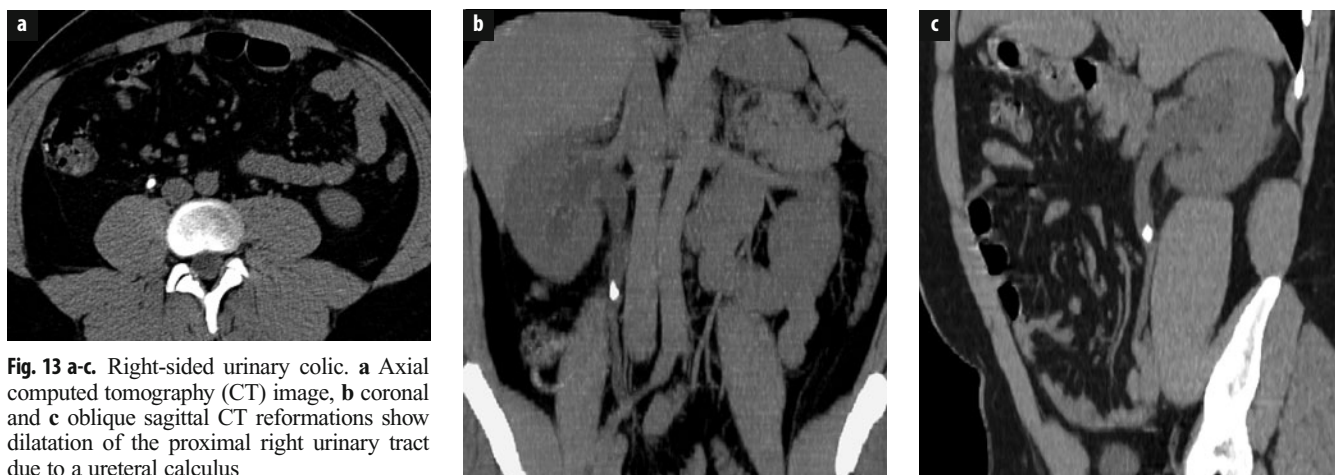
a-c. Right-sided urinary colic. a Axial computed tomography (CT) image, b coronal and c oblique sagittal CT reformations show dilatation of the proximal right urinary tract due to a ureteral calculus
